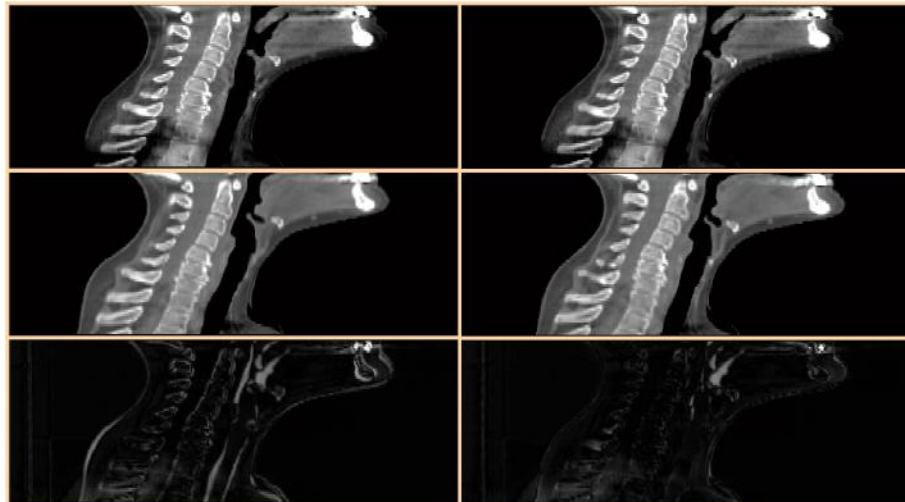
Sagittal slices of the CBCT, registered image and difference image between the two. The first column refers to a rigid-only transformation, and the second to the deformable transformation. Grey areas show where the CBCT and registered image disagree. Even though the anatomy of the head and neck is conventionally considered rigid, a rigid-only registration cannot fully capture all the changes. A rigid registration shows considerable disagreement in the bone and external contours alignment. Using deformable registration the matching is improved. Near the throat there are still discrepancies due to swallowing.
